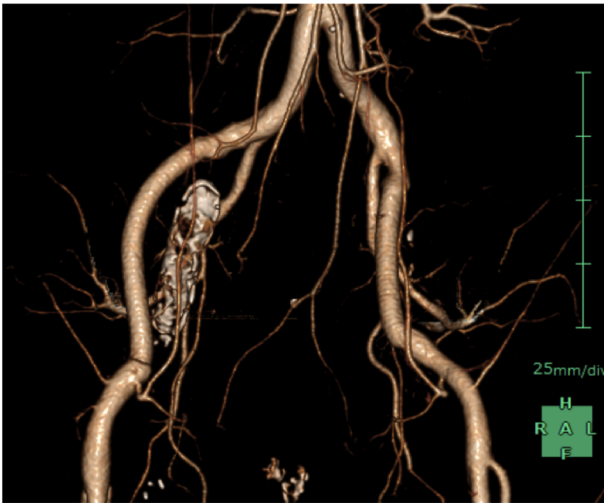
Postoperative contrast-enhanced CT showing good graft patency and no anastomotic leakage.
